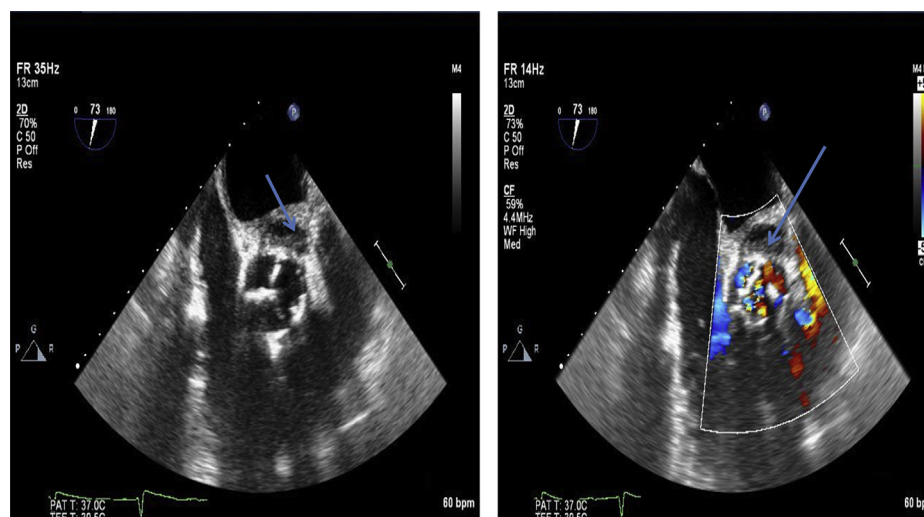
Transesophageal echocardiogram, midesophageal short-axis views showing the pseudoaneurysm (*arrows*) at the level of the aortic valve without color (*left*) and with color (*right*).
